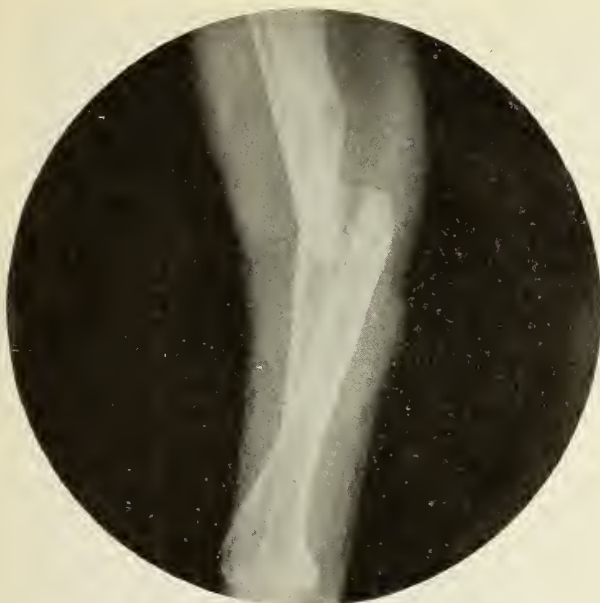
(Case 220901). X-ray before operation showing malposition and nonunion of humerus, radius and ulna.
